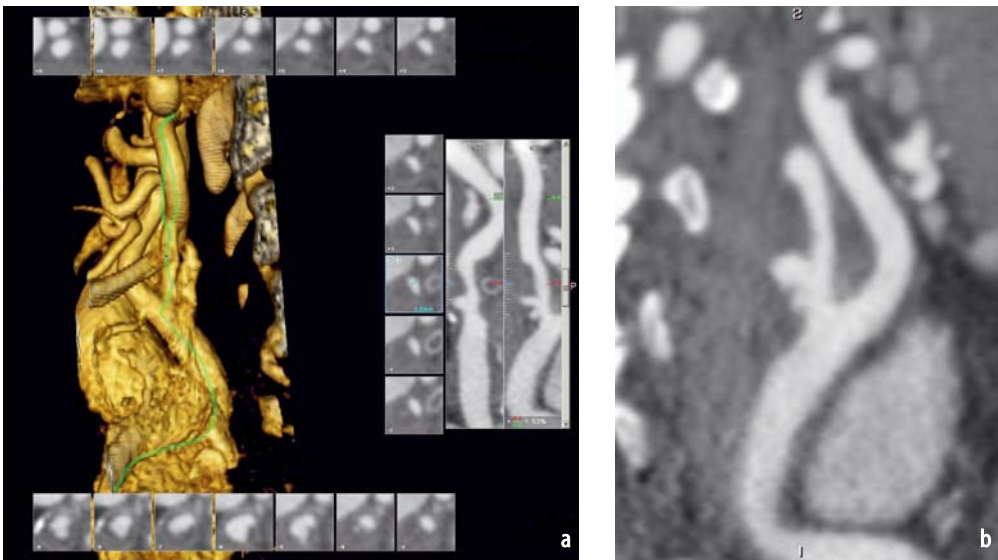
Carotid vascular disease on CTA. a Automated, curved, multiplanar reformation of carotid bifurcation. Multiple images are displayed perpendicular to the vessel long axis. Curved reformatted images to the *right* depict multiple ulcerations. The axial diameters are readily measured. b Manually trimmed sagittal maximum intensity projection (MIP) reformation also shows the multiple ulcerations with 50–55% stenosis
